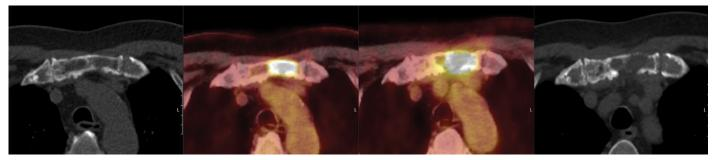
Baseline PET/CT (a, b) compared to FUs with PET (c) and CT (d) 4 and 6 months after SBRT.
